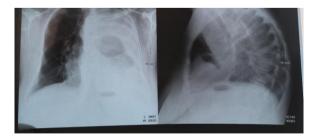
X-ray taken on admission to the emergency room.
